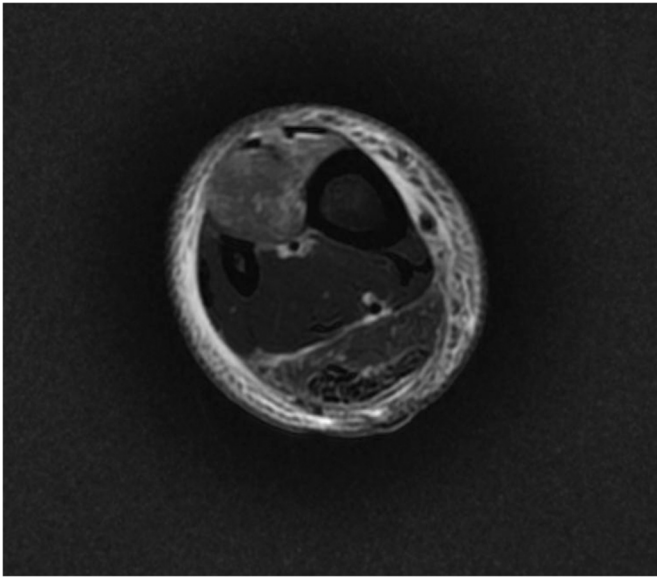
Coronal MRI of right lower limb shows enhanced signal and swelling of pre-tibial area, limiting in the anterior compartment.
